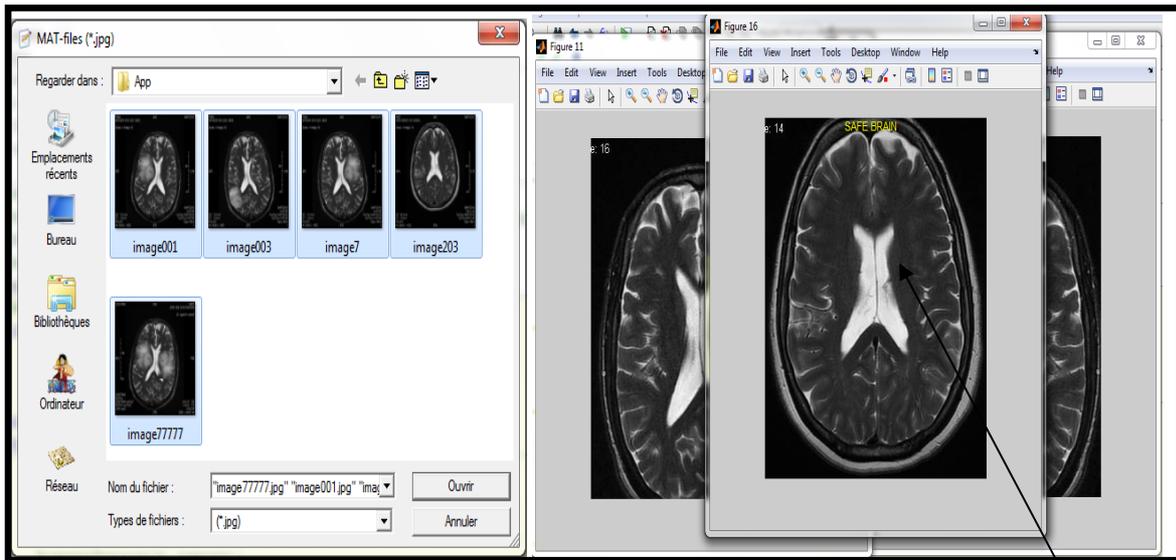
(a) Selection of multi MRI images ; Sample of normal image (safe brain)
